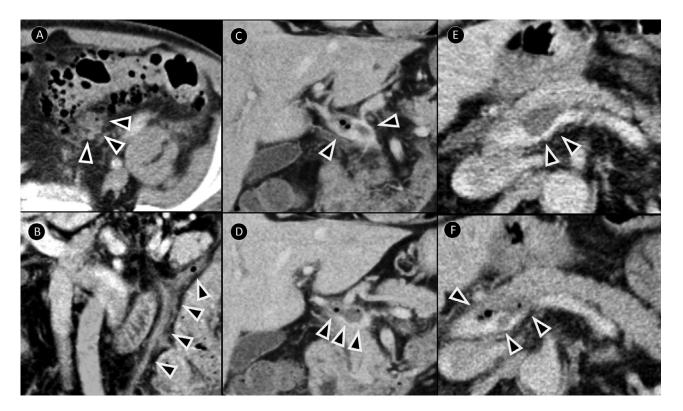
Contrast enhanced CT study of the abdomen and pelvis. (A) Axial image of the pelvis showing diffuse sigmoid diverticulitis with inflammatory phlegmon formation and locules of free air (arrowheads). (B) Coronal image demonstrating a thickened and hypoattenuating inferior mesenteric vein with intravenous gas (arrowheads). (C, D) Sequential coronal images demonstrating main portal vein thrombus with associated intravenous gas (arrowheads). (E, F) Sequential axial images demonstrating main portal vein thrombus with associated intravenous gas (arrowheads).
